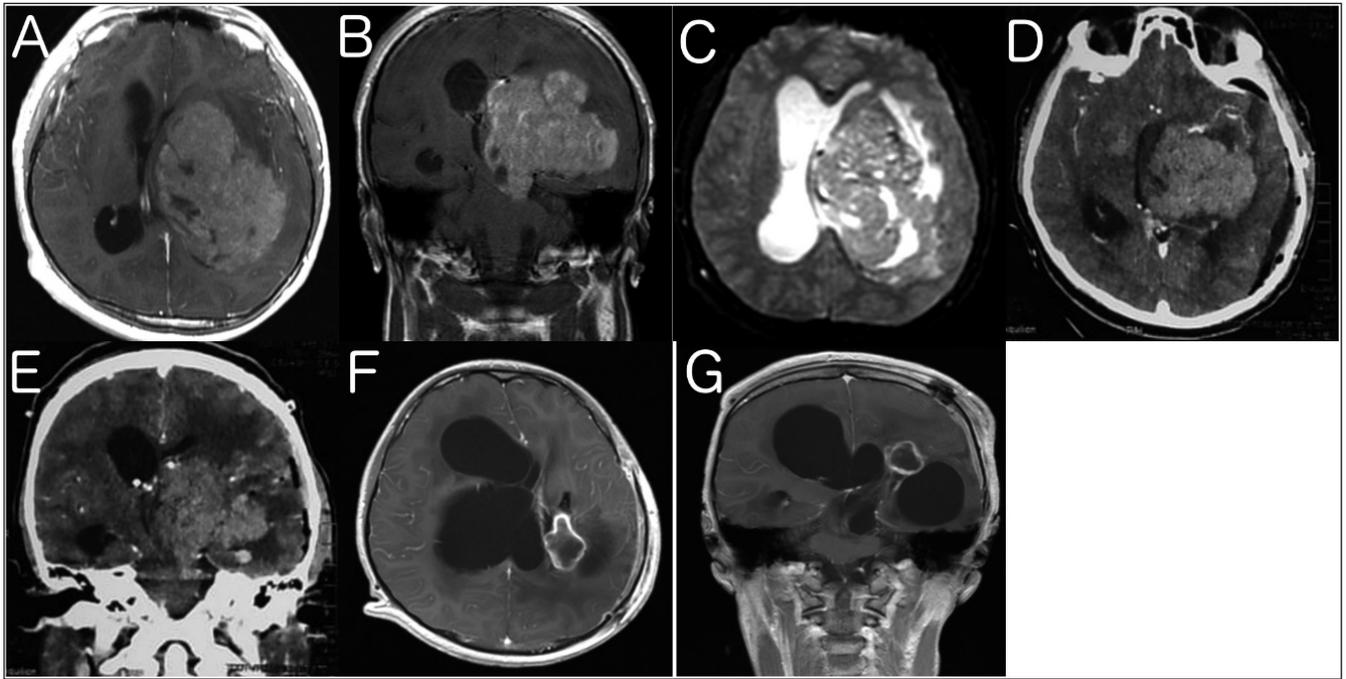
Radiological examinations; Preoperative MRI in T1-WI sequence of axial, coronal view (A, B) showing a mass in the left thalamic region with a size of 8.3x7.3x6.8 cm with heterogeneous contrast enhancement and necrotic areas; DWI sequence (C) showed restricted diffusion area suggestive of high-grade glioma; Post-operative head CT scan with contrast (D, E) showed partially resected thalamic mass with a size of 5.7x5.5x7.6 cm; Post-radiotherapy MRI (F, G) showed a satisfactory response with significant mass reduction with a size of 3.5x2.2x1.8 cm.
